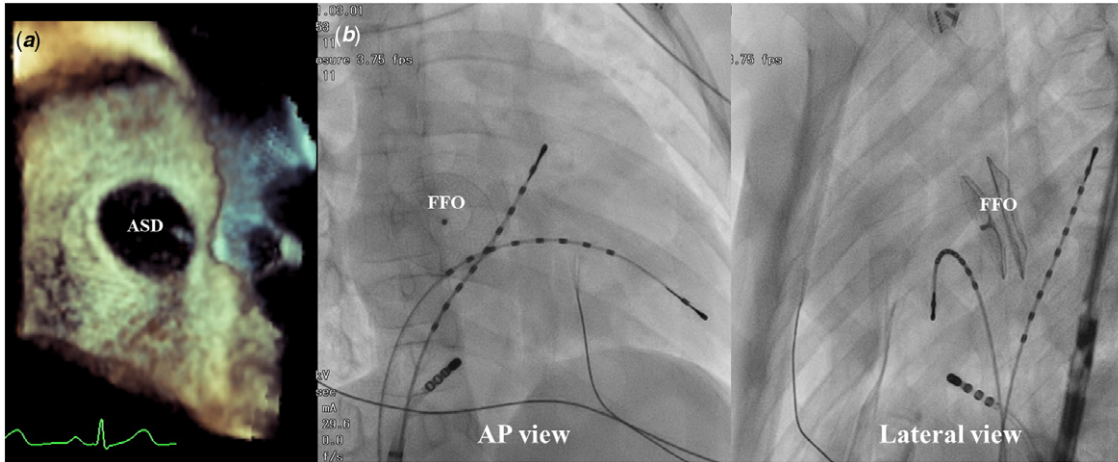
(a) ASD image of transesophageal echocardiography. (b) FFO Position on the Biplane Fluoroscopic Images. ASD, atrial septal defect; FFO, Figulla Flex & ASD Occluder™.
